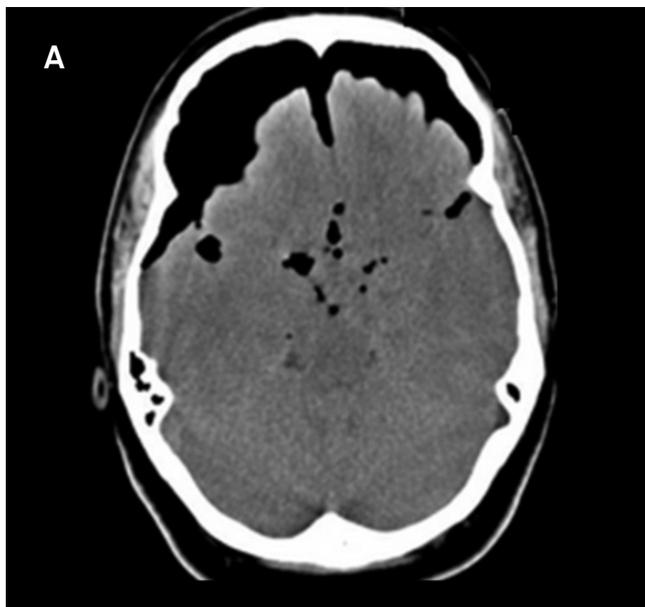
Computed tomography shows huge pneumocephalus extending from right temporal fossa and bilateral frontal region until convexity compressing supratentorial ventricular system.
